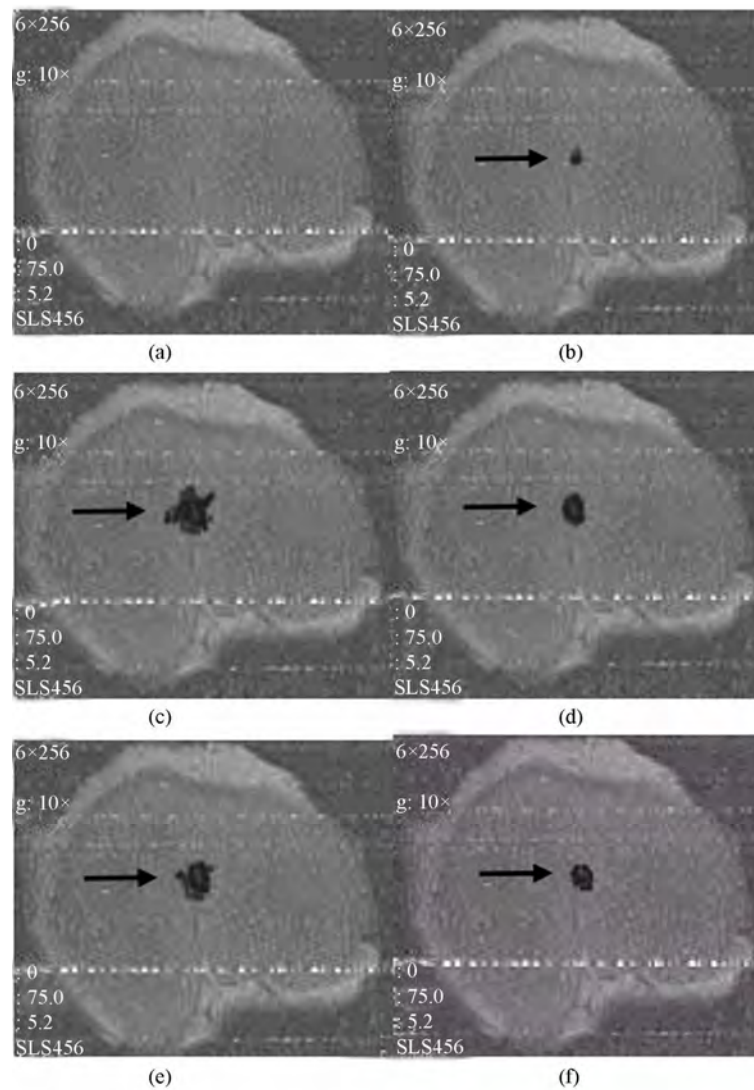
Temperature elevation *in vitro* kidney using T1- weighted FSPGR (boiling). (a) Ultrasound is OFF; (b)-(f) applied spatial average intensity: 3500 W/cm^2 (for 25 s).
